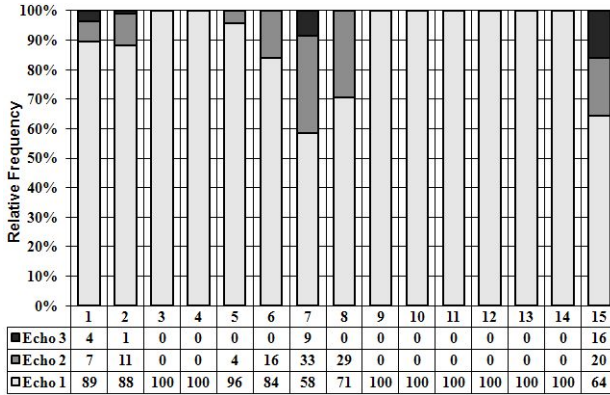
Relative frequency of different considered static environment echoes for each sensor of an ultrasonic ring
